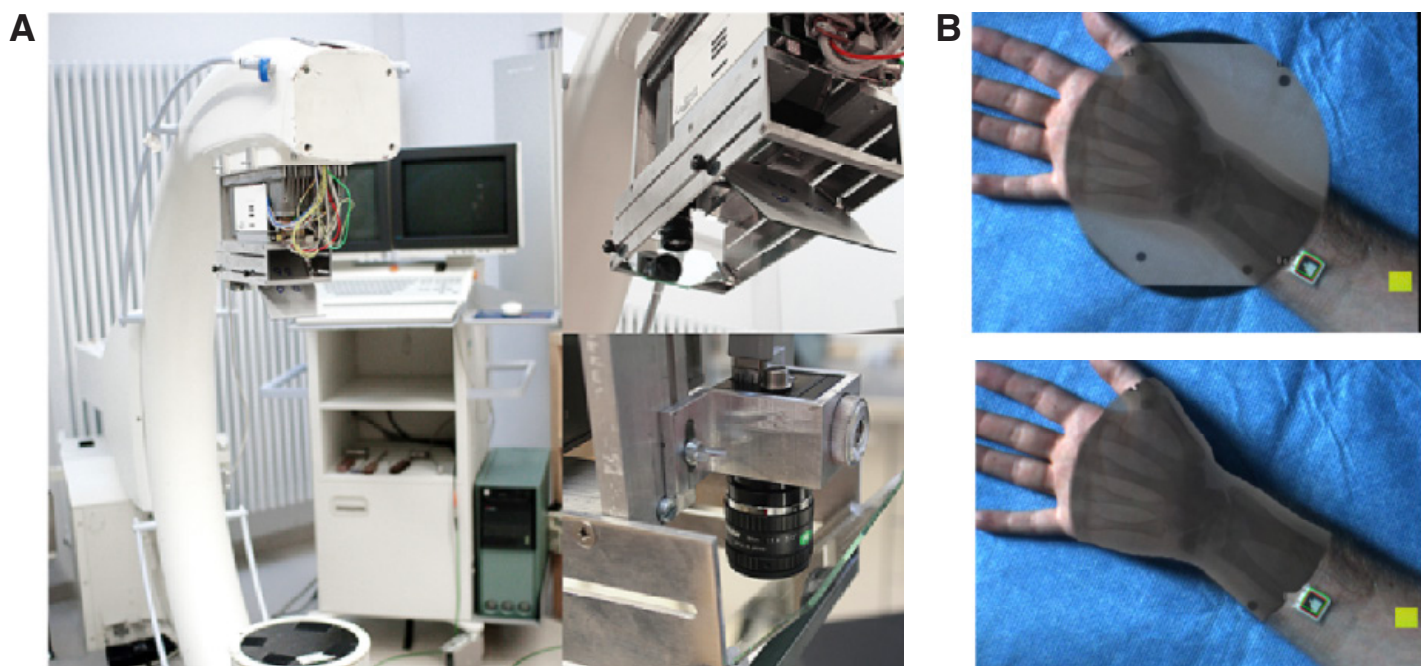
Augmented Reality Fluoroscope. A) A C-arm augmented by video camera, and B) 2D X-Ray images correctly aligned to 2D Video images.
